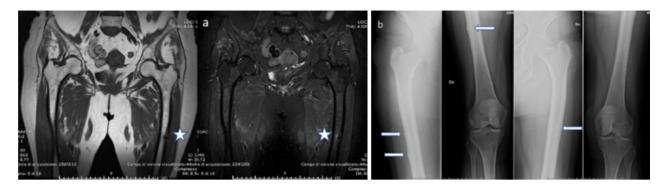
MRI images (a) and X Ray images (b) show the typical impending AFF pattern: bone edema and fracture line (*) and cortical bump (\rightarrow)
